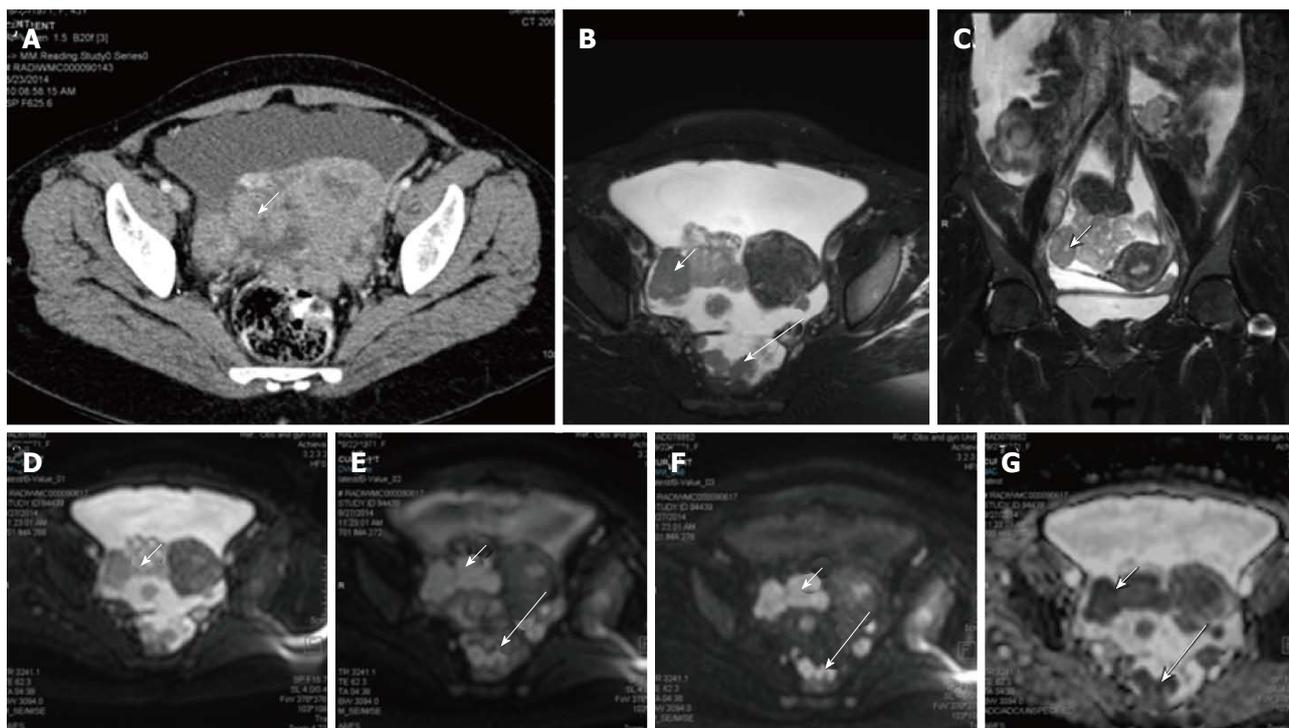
Carcinoma ovary. Axial contrast enhanced computed tomography image (A), T2 weighted axial (B) and coronal (C) images of a patient with known ovarian cancer shows right adnexal mass (arrows) multiple deposits in peritoneum of the pelvis (long arrows); On DWI, b 0 (D), b 400 (E), b 800 (F) and ADC (G) images show significant diffusion restriction in the primary (arrow) as well as peritoneal deposits (long arrow). These lesions were proven to be malignant deposits on fine needle aspiration cytology. ADC: Apparent diffusion coefficient; DWI: Diffusion weighted imaging.
